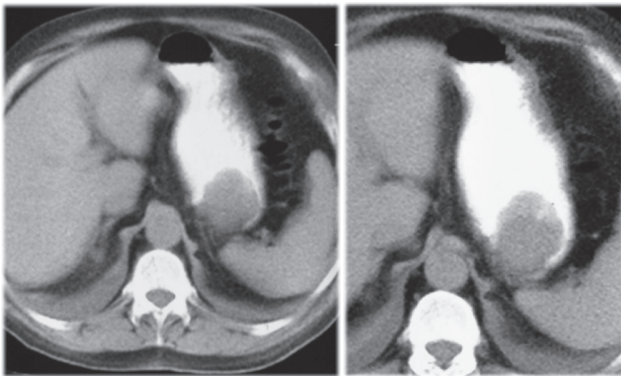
Computed tomography (CT) images of the upper abdomen in a 65-year-old male with melena. A submucosal tumor bulges in the gastric cardia.
